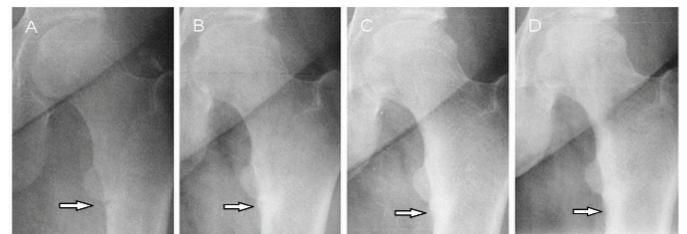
A, Fracture zone in the left femoral neck obtained before the treatment. B, Follow-up radiograph obtained 6 months after the treatment. C, Follow-up radiograph obtained 10 months after the treatment. D, Follow-up radiograph obtained 14 months after the treatment.
